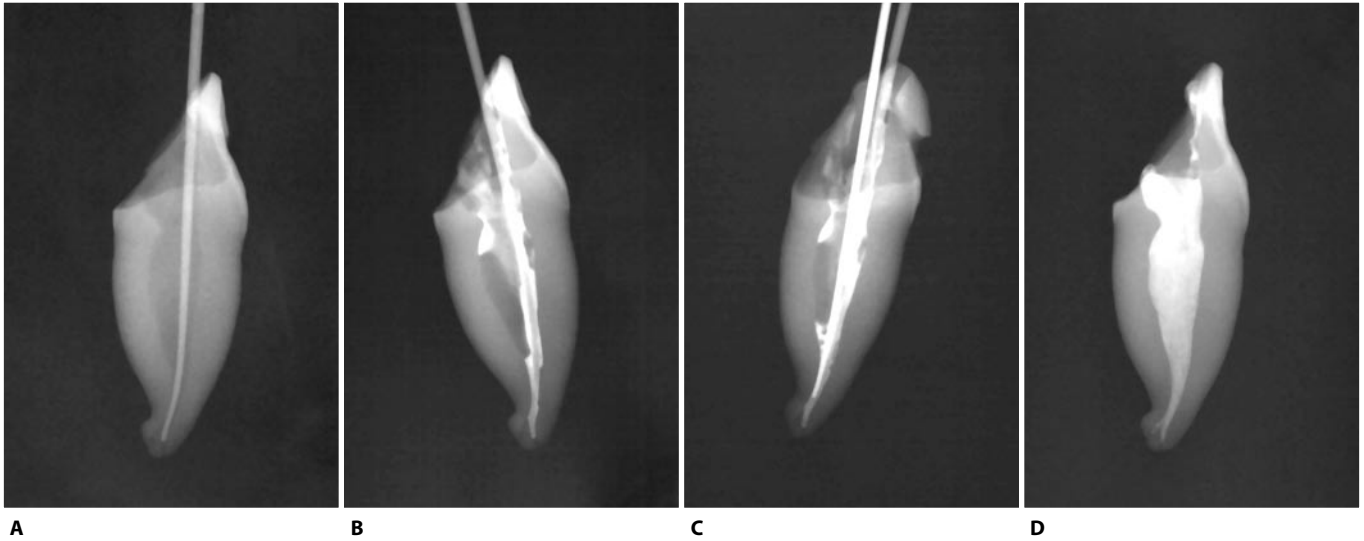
Obturation with Microseal Technique carried out on an extracted tooth. A. Selection of master cone; the correct positioning of the cone at the apex is checked radiographically. B. After having applied some cement in the coronal third of the canal, the master cone its tip having been smeared with sealer is introduced in the canal. C. The master cone is condensed by bringing a spreader in NiTi up to 2-3mm from the apex. D. The root canal appears completely filled with a homogenous mass of gutta-percha.
